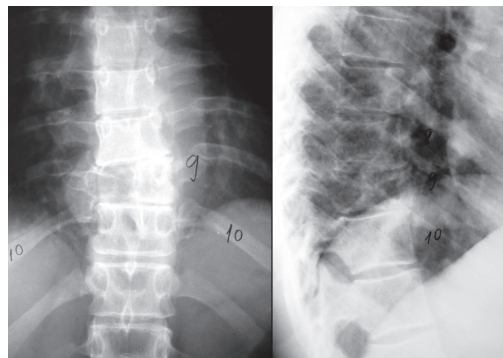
X-ray of lithic lesion, with bone expansion, erosion and cortical destruction.
